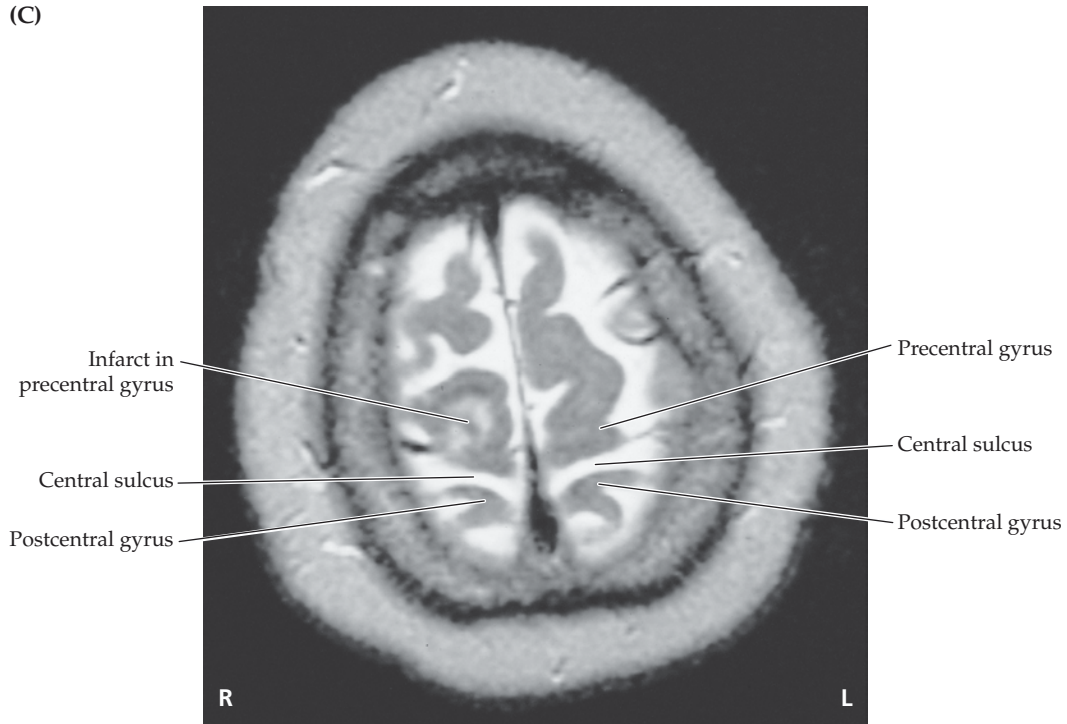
Infarct in Right Precentral Gyrus Leg Area (A–C) Sequentially higher axial (horizontal) T2-weighted MRI images. The infarct in the right precentral
